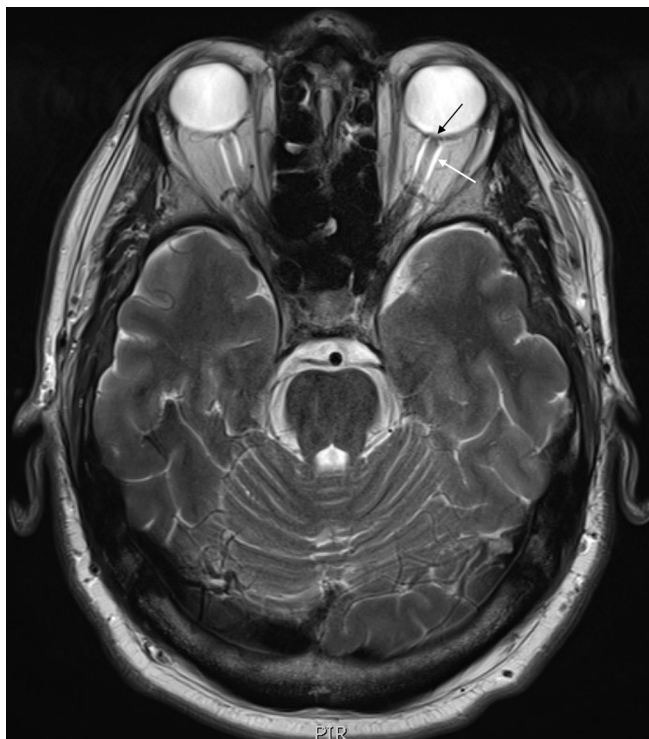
MRI head and optic nerve. T2 axial image of MRI head (black arrow): bulging of the left optic nerve head. White arrow: fluid around the optic nerve sheath bilaterally, left more than right.
